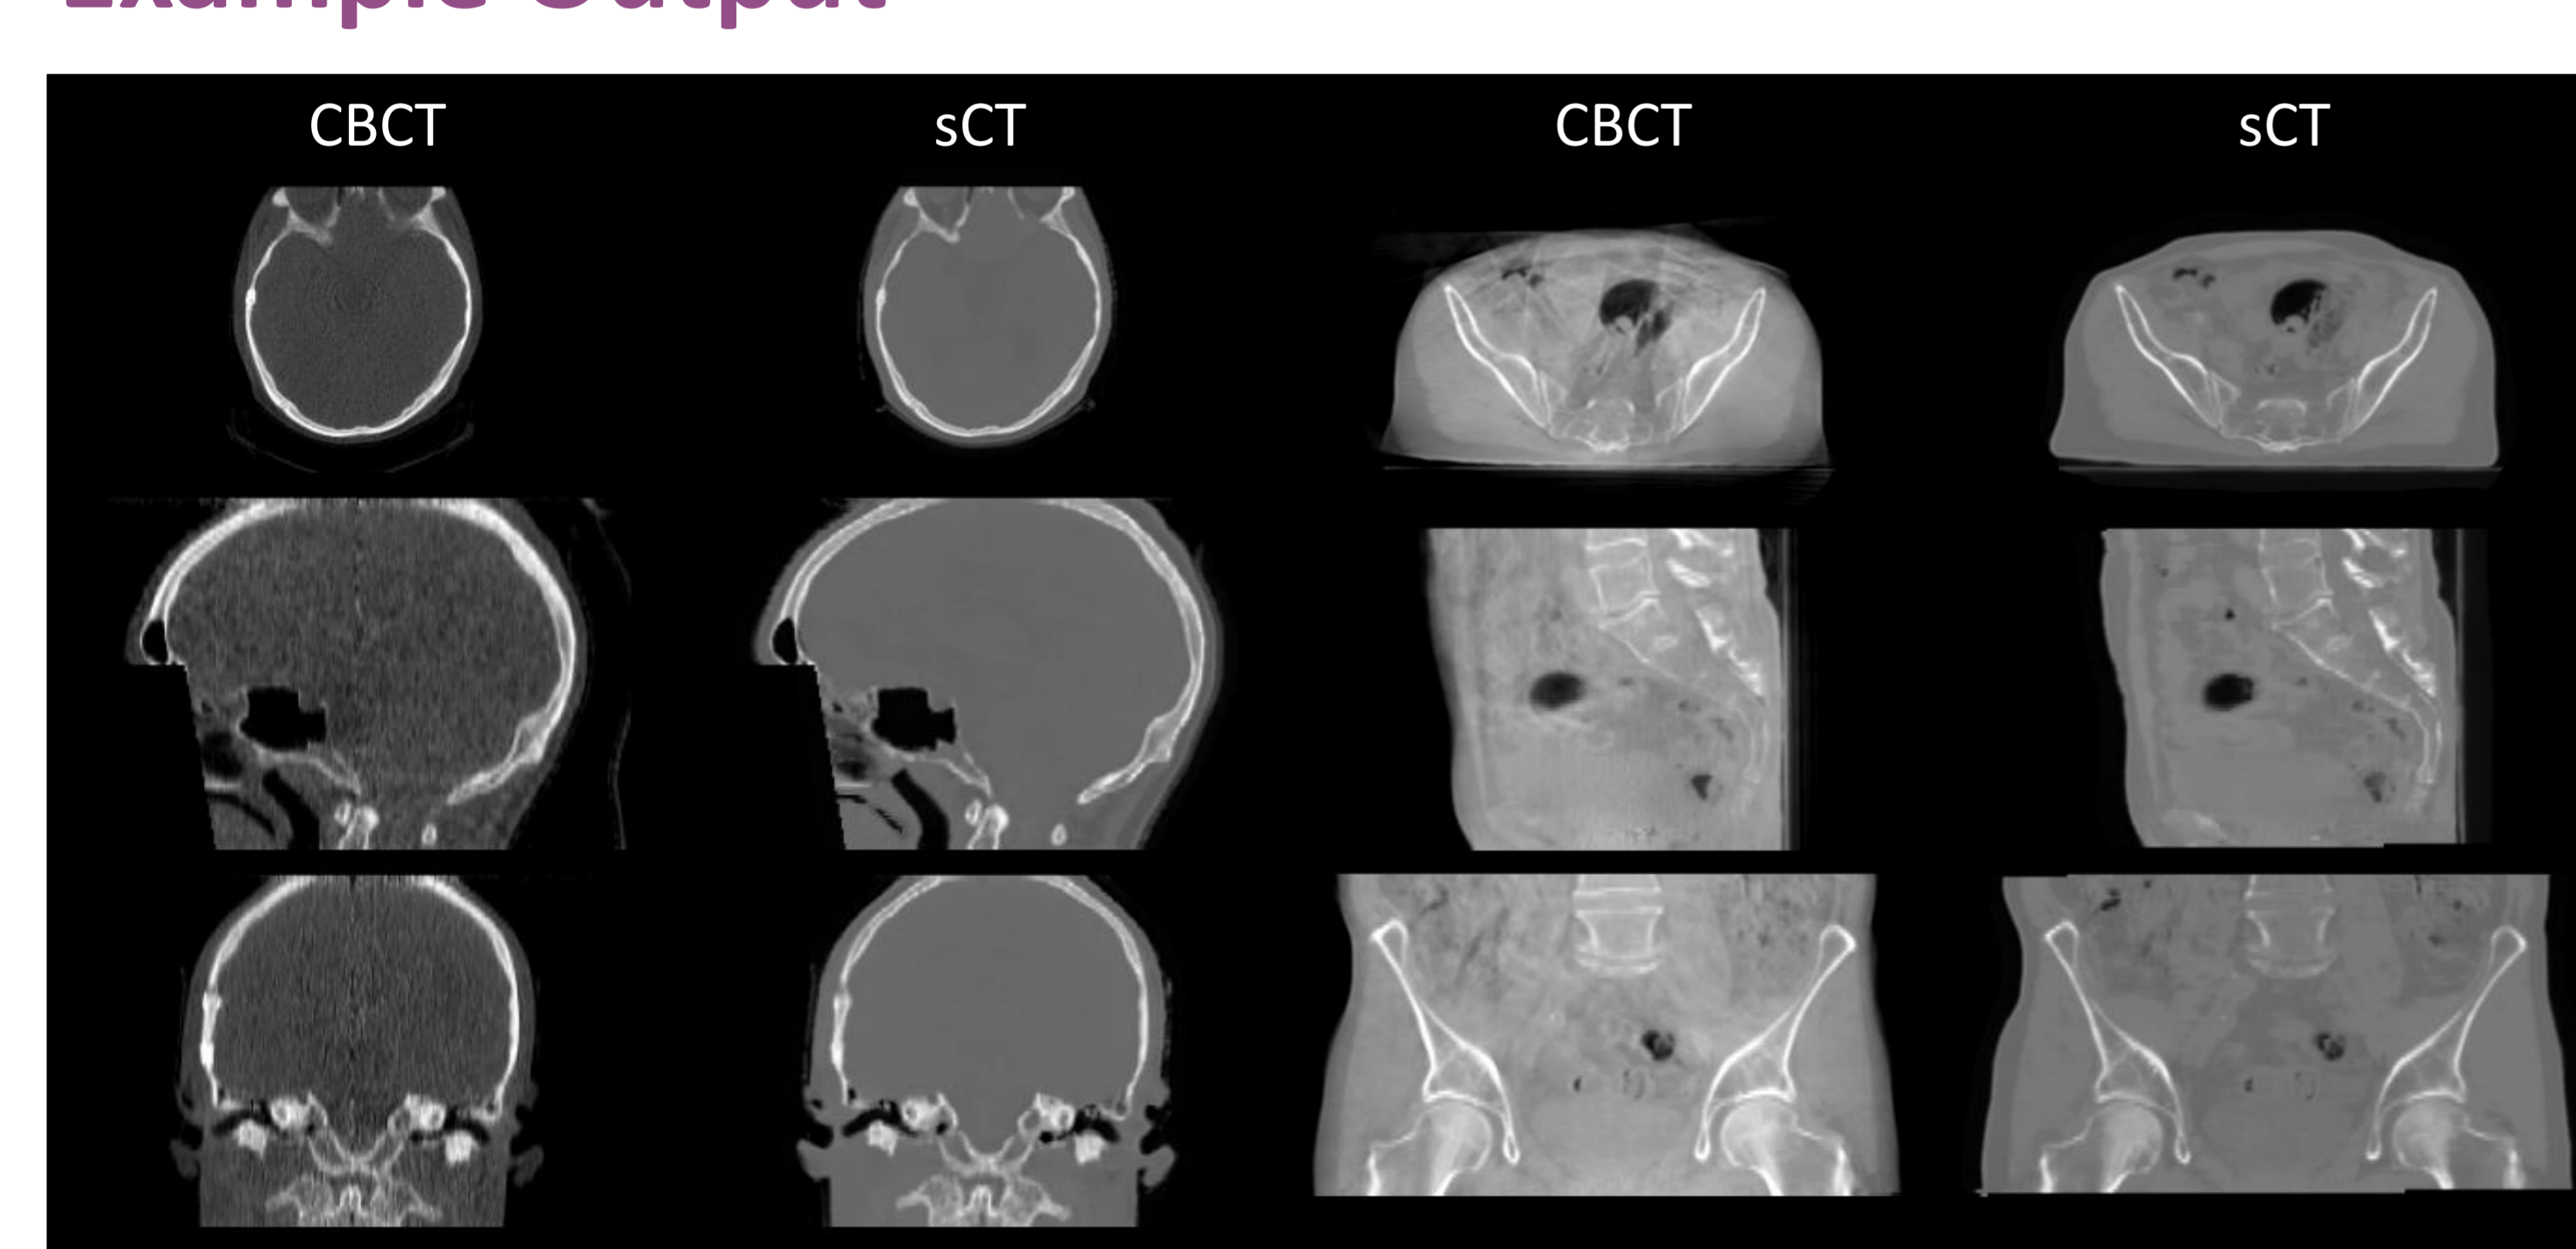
Example test phase CBCT and sCT generated by our methods. Pelvis and brain results are shown with HU scale of [-400,1200] and [250, 2500], respectively.
